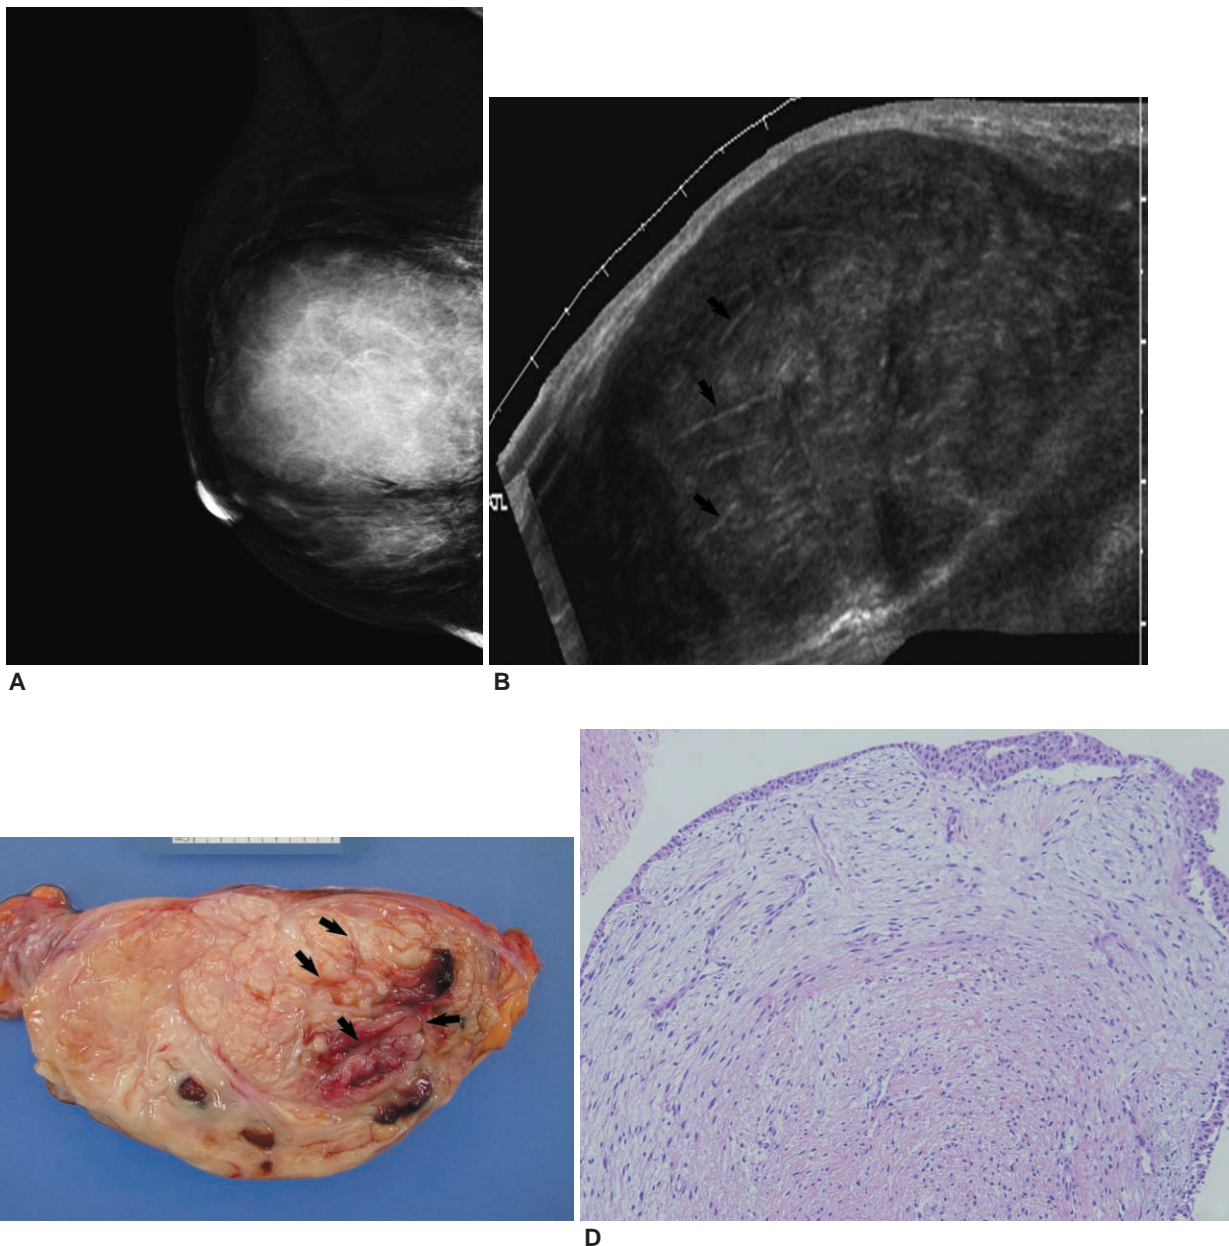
A 53-year-old woman with a palpable right breast mass that was surgically confirmed to be phyllodes tumor. The result of sonographically guided core needle biopsy was benign phyllodes tumor.
